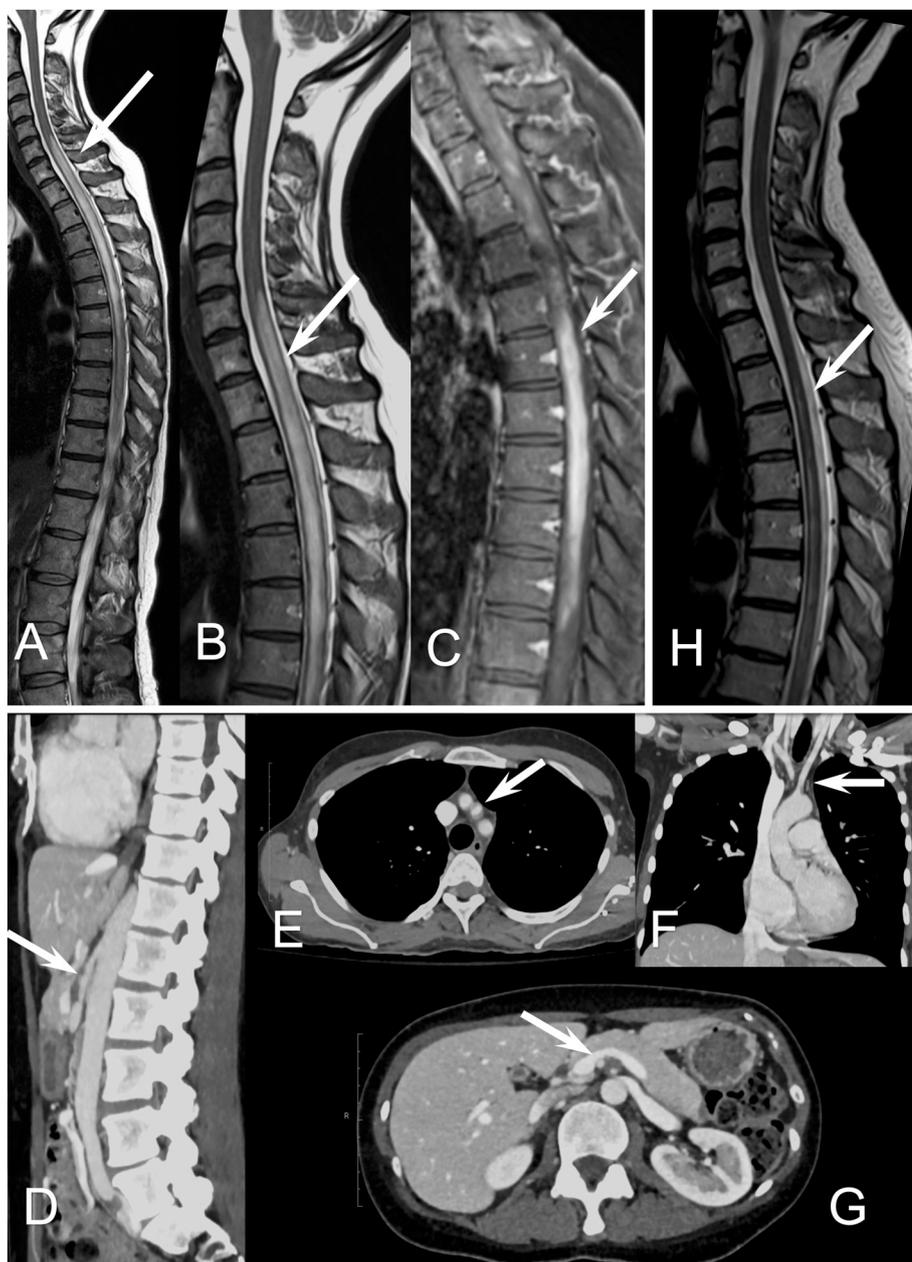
Magnetic resonance image (MRI) of the patient's spine, and computed tomography of the patient's thorax and abdomen. (A) Spinal sagittal T2-weighted image show high signal from C6 to the conus medullaris, as well as (B) the cervical sagittal T2-weighted image, both confirming a longitudinally extensive transverse myelitis that (C) in the post-gadolinium T1-weighted image displays heterogeneous contrast enhancement from Th3 to Th8. (D) The thoracic-abdominal computed tomography shows mural thickening of the mesenteric superior artery, (E and F) the brachiocephalic trunk, and (G) right renal artery, confirming the presence of Takayasu arteritis. (H) Follow-up after one year: the spinal sagittal T2-weighted image shows regression of the inflammatory lesion.
